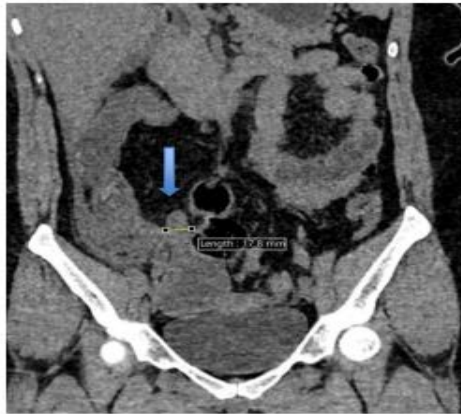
CT Abdomen Coronal Plane Showing Dilated Appendix (Blue arrow)
